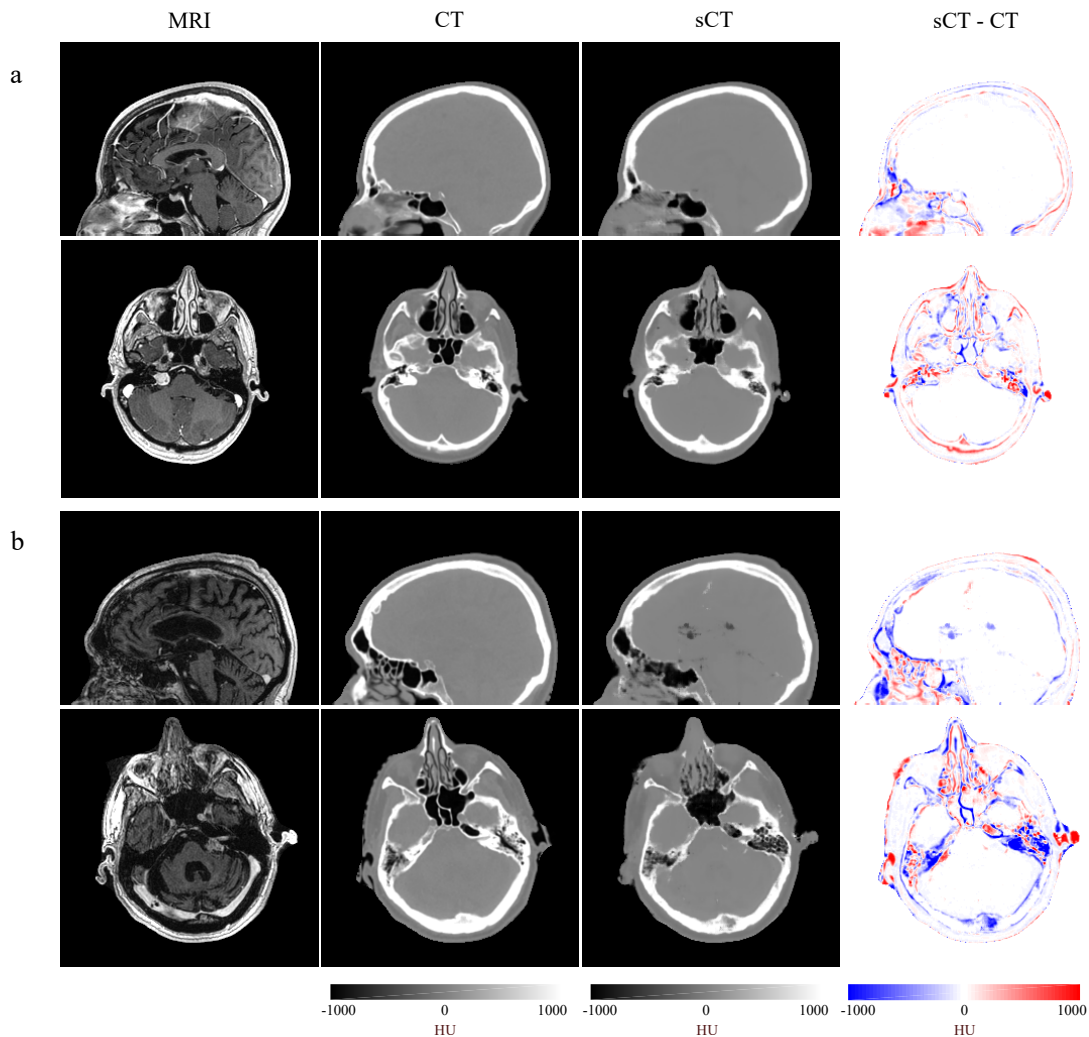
Sagittal (mid-plane) and axial (nasal level) views of MRI (input to 3D GAN), CT, synthetic CT and corresponding difference maps for a) a representative patient with  $MAE_{Body} = 62$  HU and b) worst quality case with  $MAE_{Body} = 98$  HU.
